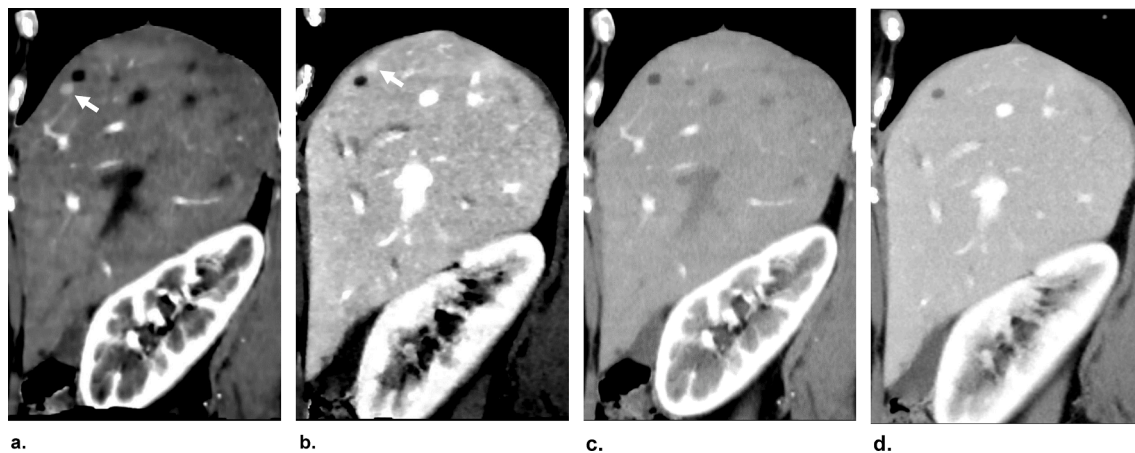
Characteristic artifacts near cyst in CE-boost images. Sagittal images on (a) CE-boost (LA-PV), (b) CE-boost (PV-LA), (c) LAP, and (d) PVP images. A high attenuation area is seen adjacent to the edge of the liver cyst in the CE-boost (LA-PV) image (arrow in a). A similar high attenuation area is depicted on the opposite side of the cyst in the CE-boost (PV-LA) image (arrow in b). These artifacts are not observed in the multiphasic CE-CT images (c, d). Although characteristic artifacts are seen, misregistration on the liver contour is not obvious (a, b). Sagittal images are presented to better show the relative position of the cyst and the artifact. CE-boost, contrast enhancement boost; LA-PV, PVP subtracted from LAP; PV-LA, LAP subtracted from PVP; LAP, late arterial phase; PVP, portal venous phase; CE-CT, contrast-enhanced CT.
